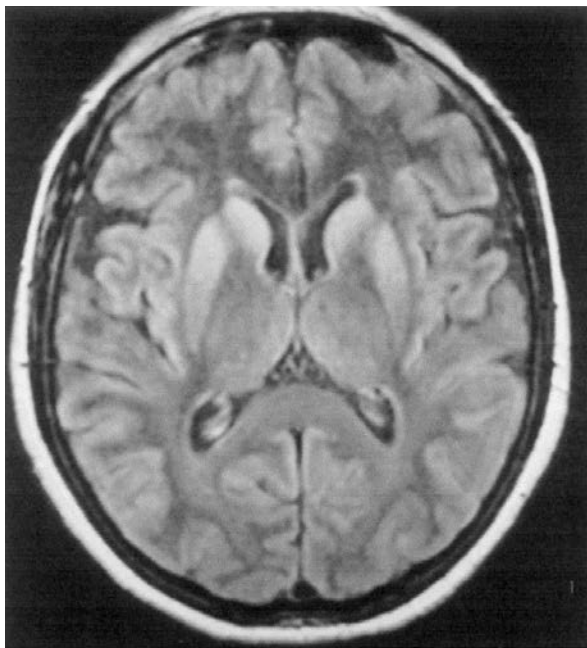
Sporadic CJD: FLAIR axial image. High signal is seen in the putamen and caudate head laterally.
